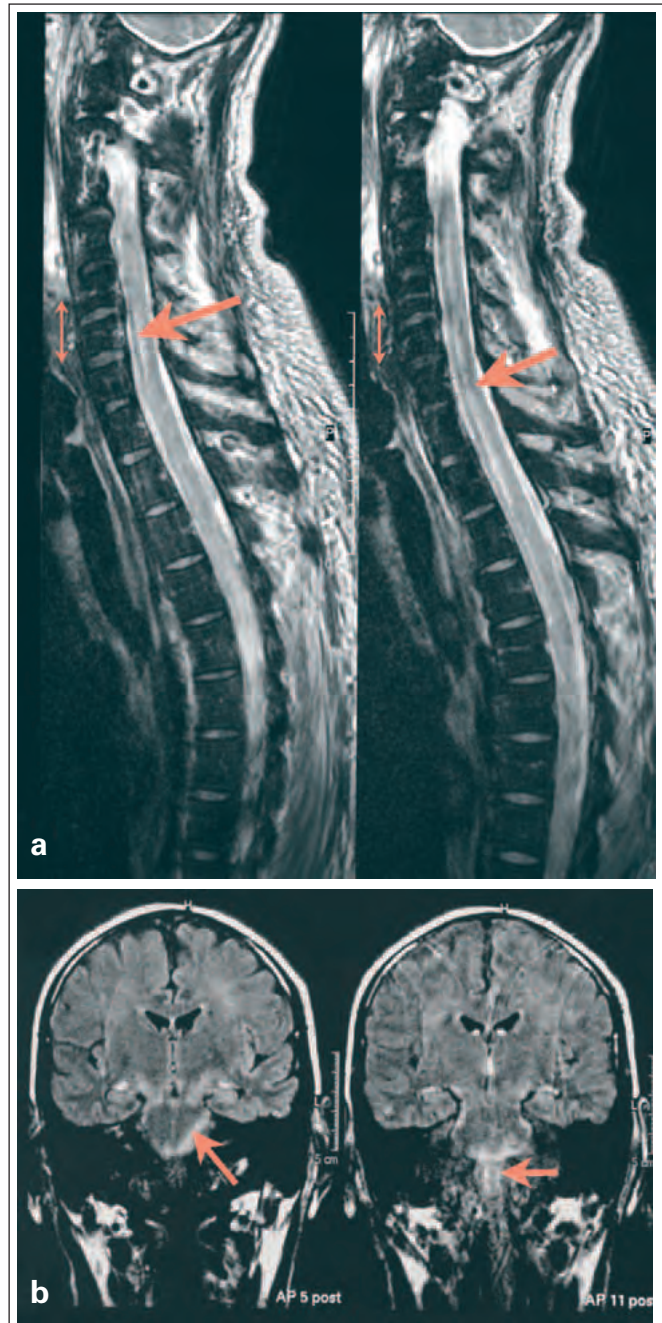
(a) MRI (T2-weighted) of the cervicothoracic spine showing extensive myelopathy (arrows) after intrathecal MTX 12 mg, Ara-C 30 mg + prednisolone 2.5 mg in a 31-year-old male treated for leukaemia ("triple therapy"): tetraplegia developing over 24 hours shortly after application. (b) Cerebral MRI of the same patient (FLAIR) showing affection of the pons (arrow) and medulla (arrow) resulting in coma and mechanic ventilation. Incomplete recovery with persistent paraparesis and severe bilateral hyakusis.
